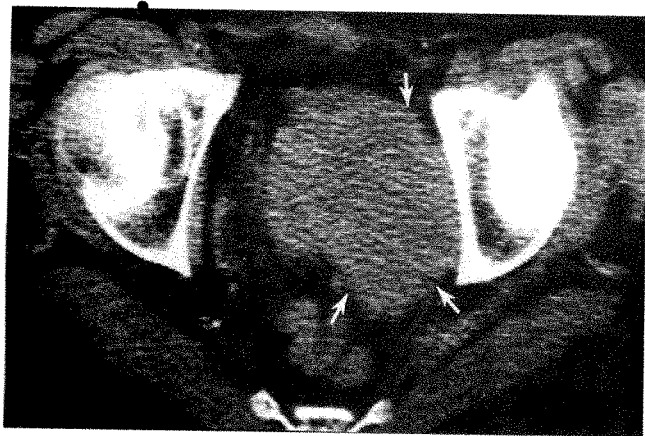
75-year-old man with hematuria. Extensive transitional cell carcinoma involving left side of bladder seen on cystoscopy; uncertain extravesical extent. CT scan showing large tumor mass arising from bladder and extending through peripelvic fat to left lateral pelvic wall (arrows). Surgical confirmation.
